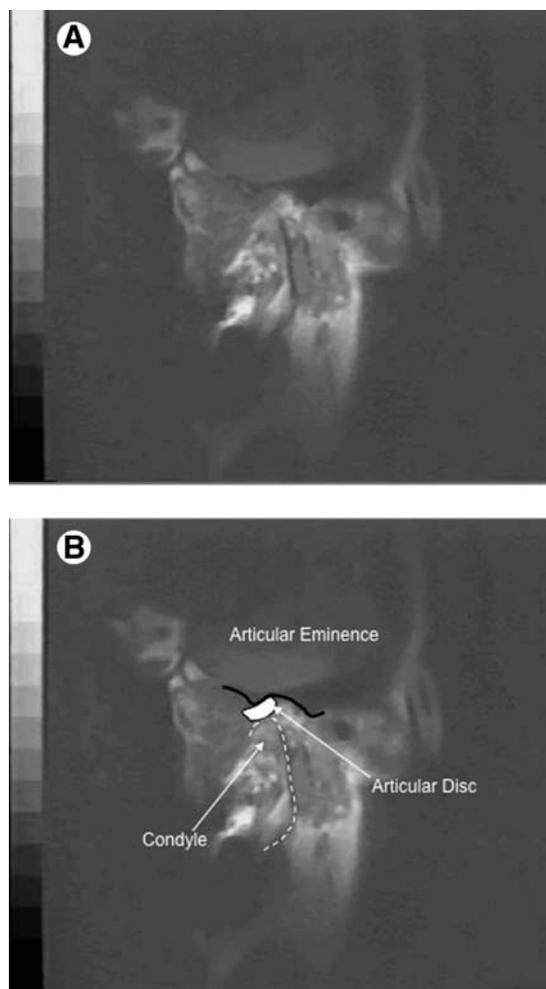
(A) Postdistraction MRI in an open position showing morphology of the affected TMJ. Note the change in the morphology of the squamous part of the temporal bone, which now has a putative glenoid fossa and articular eminence, consistent with the formation of the rudimentary elements of a new TMJ. There is also increased signal intensity in the region of the pseudodisk. There is improved condylar motion, with hinge movement followed by displacement down the rudimentary articular eminence consistent with a normal joint articulation. (B) Outline and labels for A.
